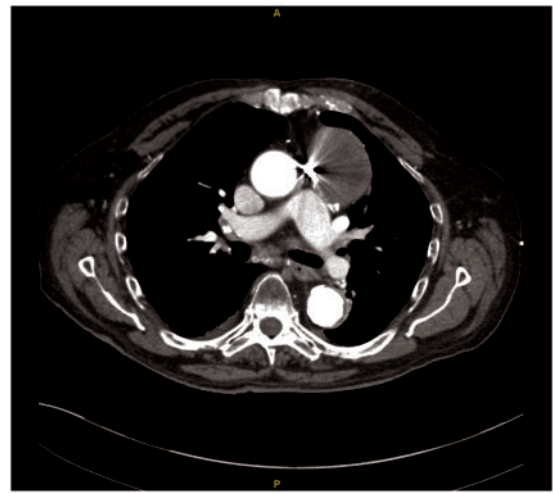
Follow-up 10 month CTA. The previously seen and coiled pseudoaneurysm is completely thrombosed.
